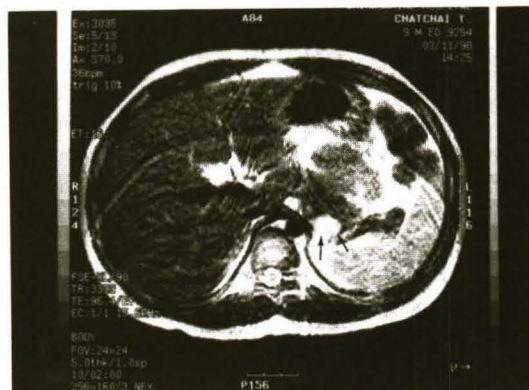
Insulinoma. MRI axial T2 weighted FSE (TR = 3333 msec, TE = 96.4 msec) Reveals a marked hyperintense mass at posterior aspect of pancreas. (small arrows)
